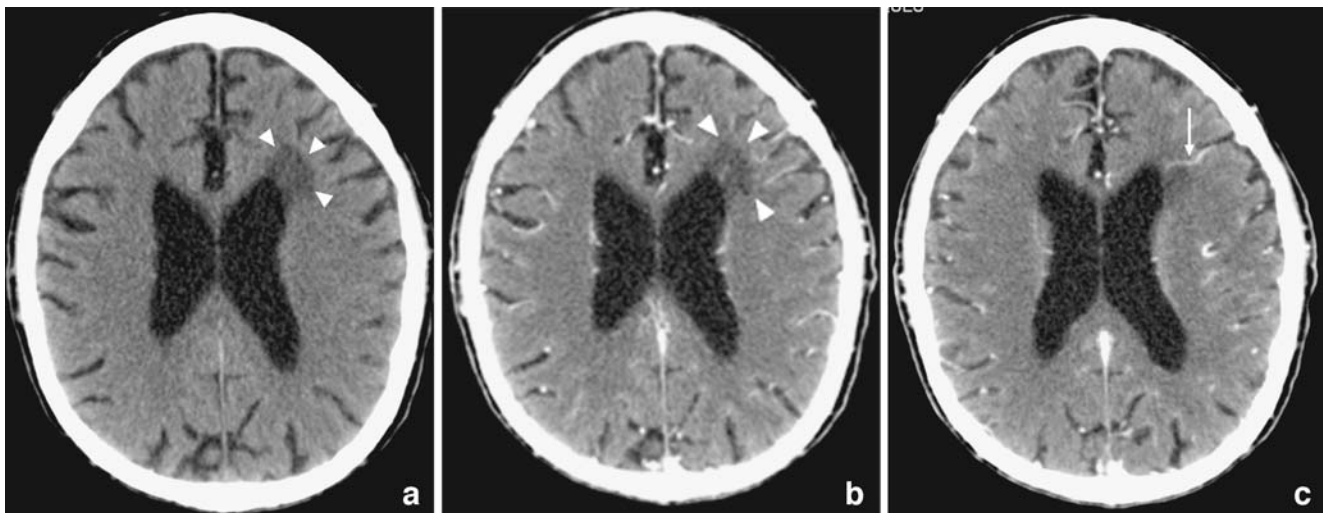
A 40-year-old alcoholic male presenting with seizure. a Non-contrast computed tomography (CT) showing a left frontal horn, periventricular white matter hypodensity (*arrowheads*) with no mass effect. b, c Post-contrast CT showing a small underlying frontal DVA with superficial drainage (*white arrow*) whose medullary veins are found within the hypodense area demarcated by the *arrowheads* in a
